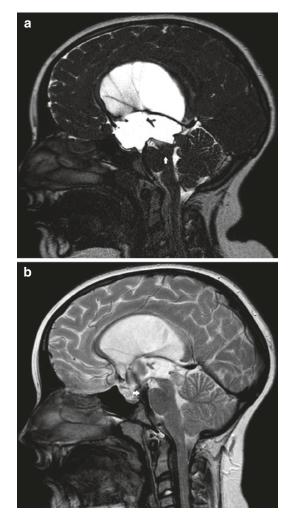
Pre-operative (a) and postoperative (b) CINE sequence sagittal MRI images demonstrating hydrocephalus secondary to a tectal plate tumour (*white arrow*) causing aqueduct stenosis. Again note the depressed floor of the third ventricle in (a). This was treated with Endoscopic third ventriculostomy. Note the flow void through the ventriculostomy (*white arrow*) in (b)
